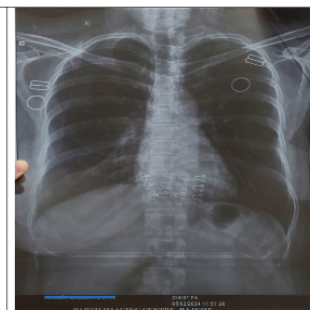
chest radiograph dated on 05/02/24
